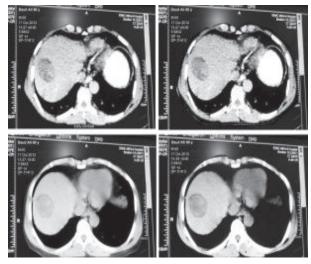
Triple phase axial CT scan showing a well marginated HCC in right lobe of liver showing hyper attenuation in AP & wash out of contrast in PVP & delayed phase.
